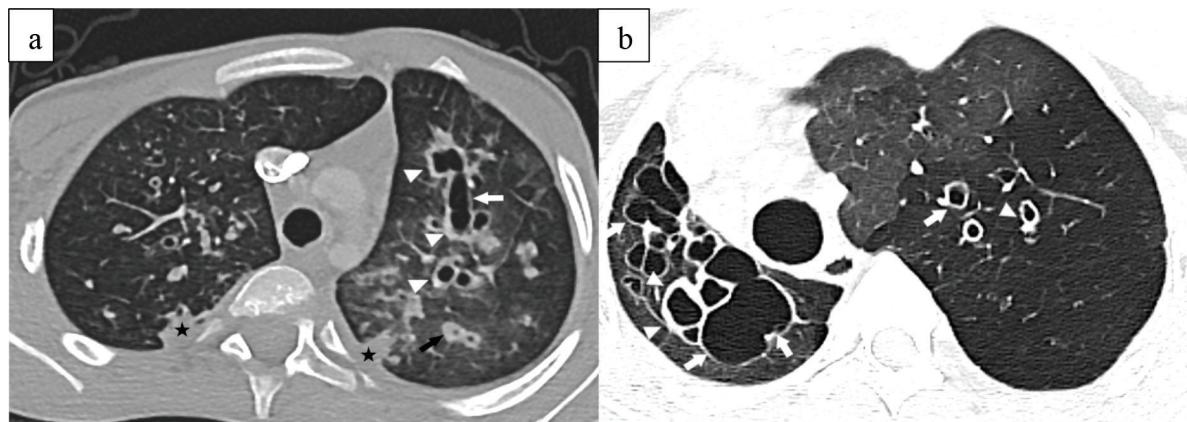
(a) Cystic bronchiectasis (white arrow) with accompanying peribronchial thickening (white arrowhead) in the left lung on thoracic CT. Ground-glass opacities and subpleural consolidation areas (indicated by a black star), more prominent in the left lung, are also observed. A mucus plug is visible within one of the bronchiectatic airways (indicated by the black arrow). (b) Large cystic bronchiectasis (white arrow) with peribronchial thickening (white arrowhead) observed in the right lung. Notable volume loss and rightward shift of mediastinal structures are also present. In the left lung, finer-caliber bronchiectasis (indicated by the white arrow) and mosaic attenuation are observed.
